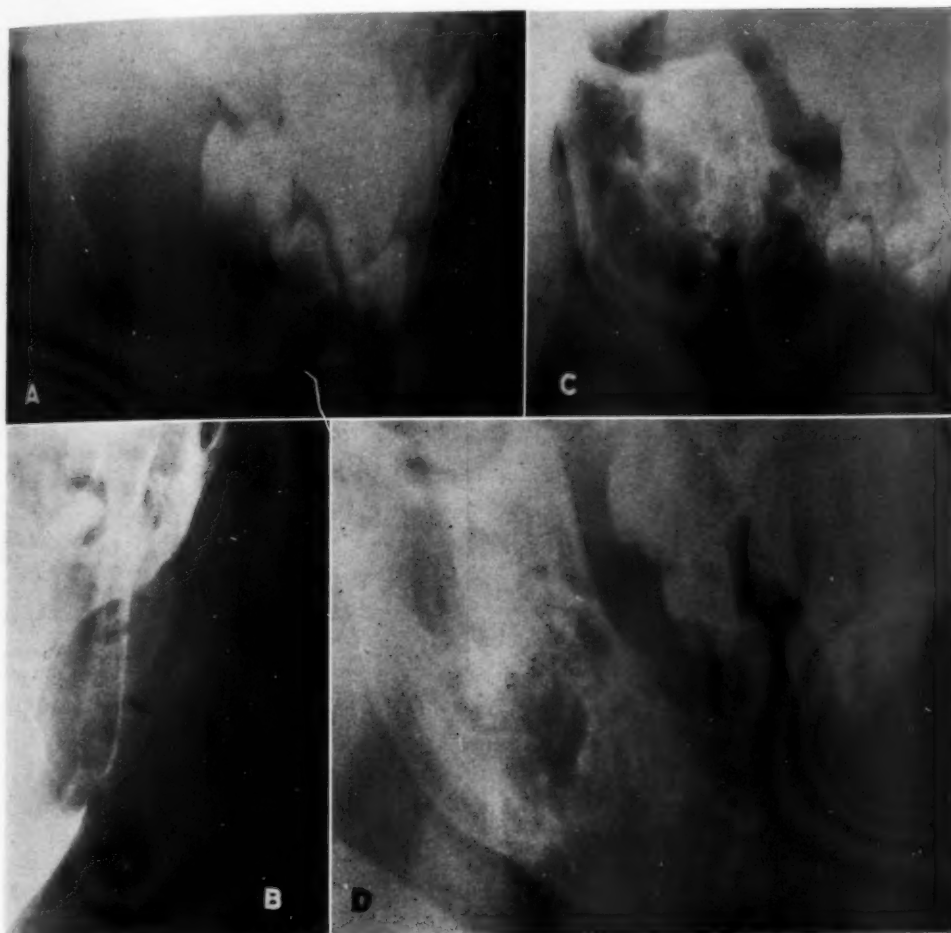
Case 1. A. Ossifying fibroma seen as a unilocular, structureless lesion displacing adjacent tooth. B. Sagittal view showing egg-shell margin of tumor. C. Evidence of recurrence ten months after surgical treatment. D. Five years after x-ray treatment for the recurrence there is some improvement in configuration of the mandible with increased density and no evidence of active tumor.
